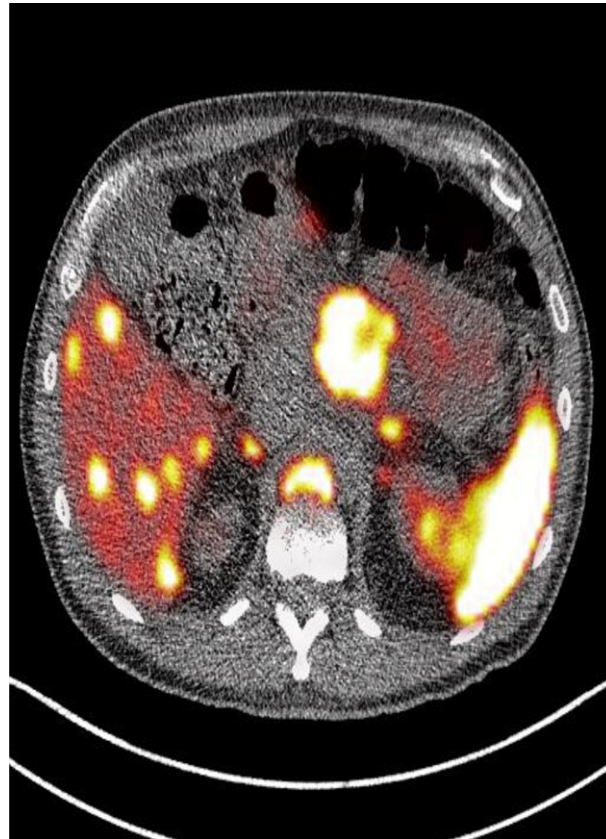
68-Gallium-DOTATATE PET/CT showing intense uptake in pancreatic tumor and multiple liver metastases. Physiologic uptake in the spleen.
